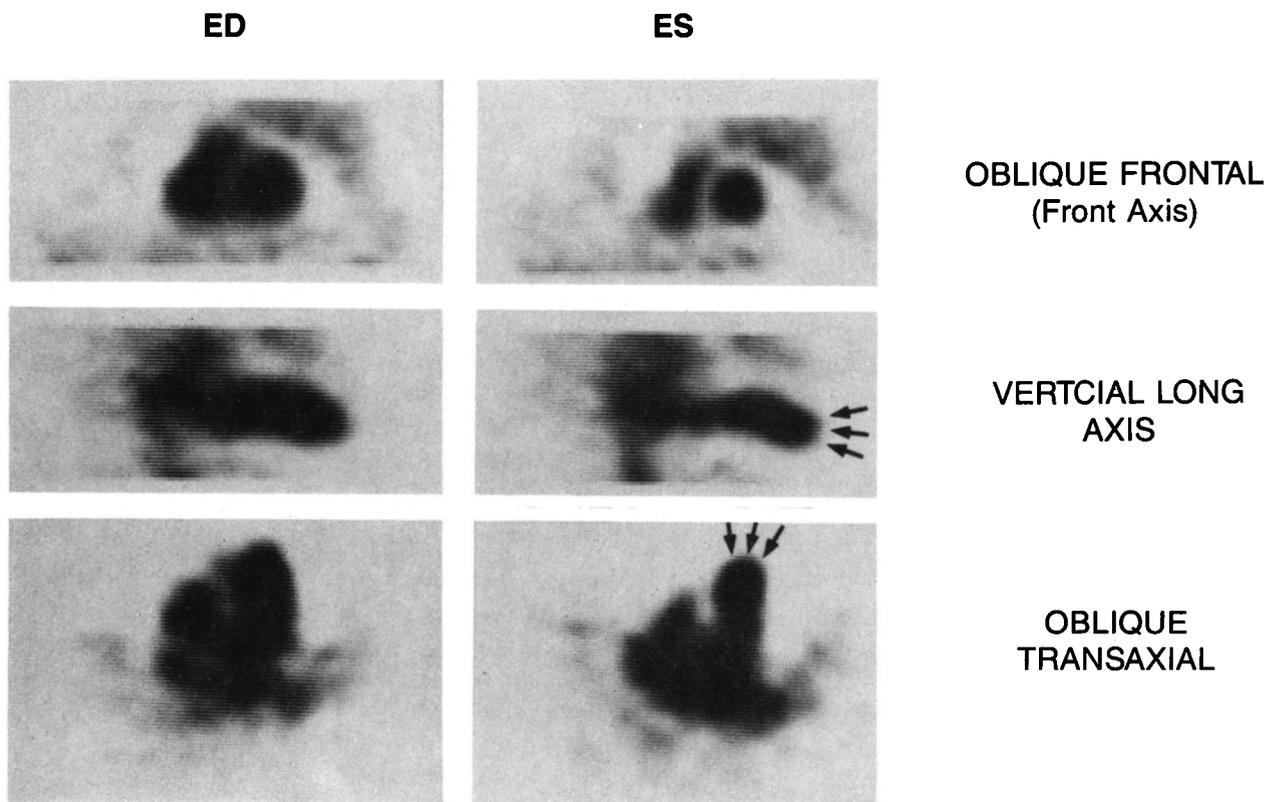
Dual gated GSPECT oblique mid-ventricular slices (12 mm thick) of a patient with anterolateral akinesis. Arrows indicate area of akinesis.
